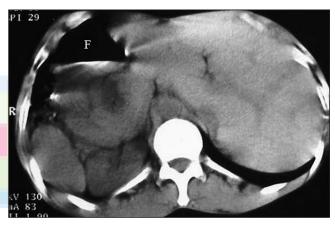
Computed tomography scan showing situs inversus (F denotes fundus)
